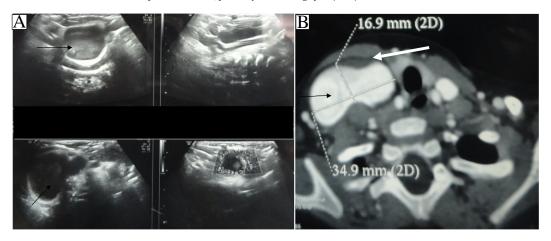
(A) Doppler ultrasound and (B) contrast enhanced computed tomography (CECT) of the neck showing right internal jugular vein phlebectasia (black arrow) with pseudocapsule (white arrow).
